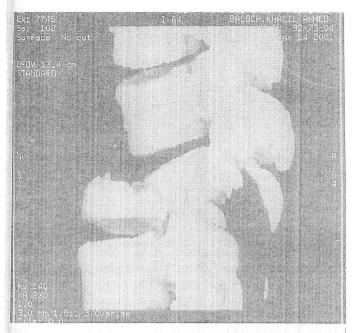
CT scan of lumbar spine with 3D reformation showing lateral view of "Chance-type" flexion-rotation fracture-dislocation of L-2 vertebra.
